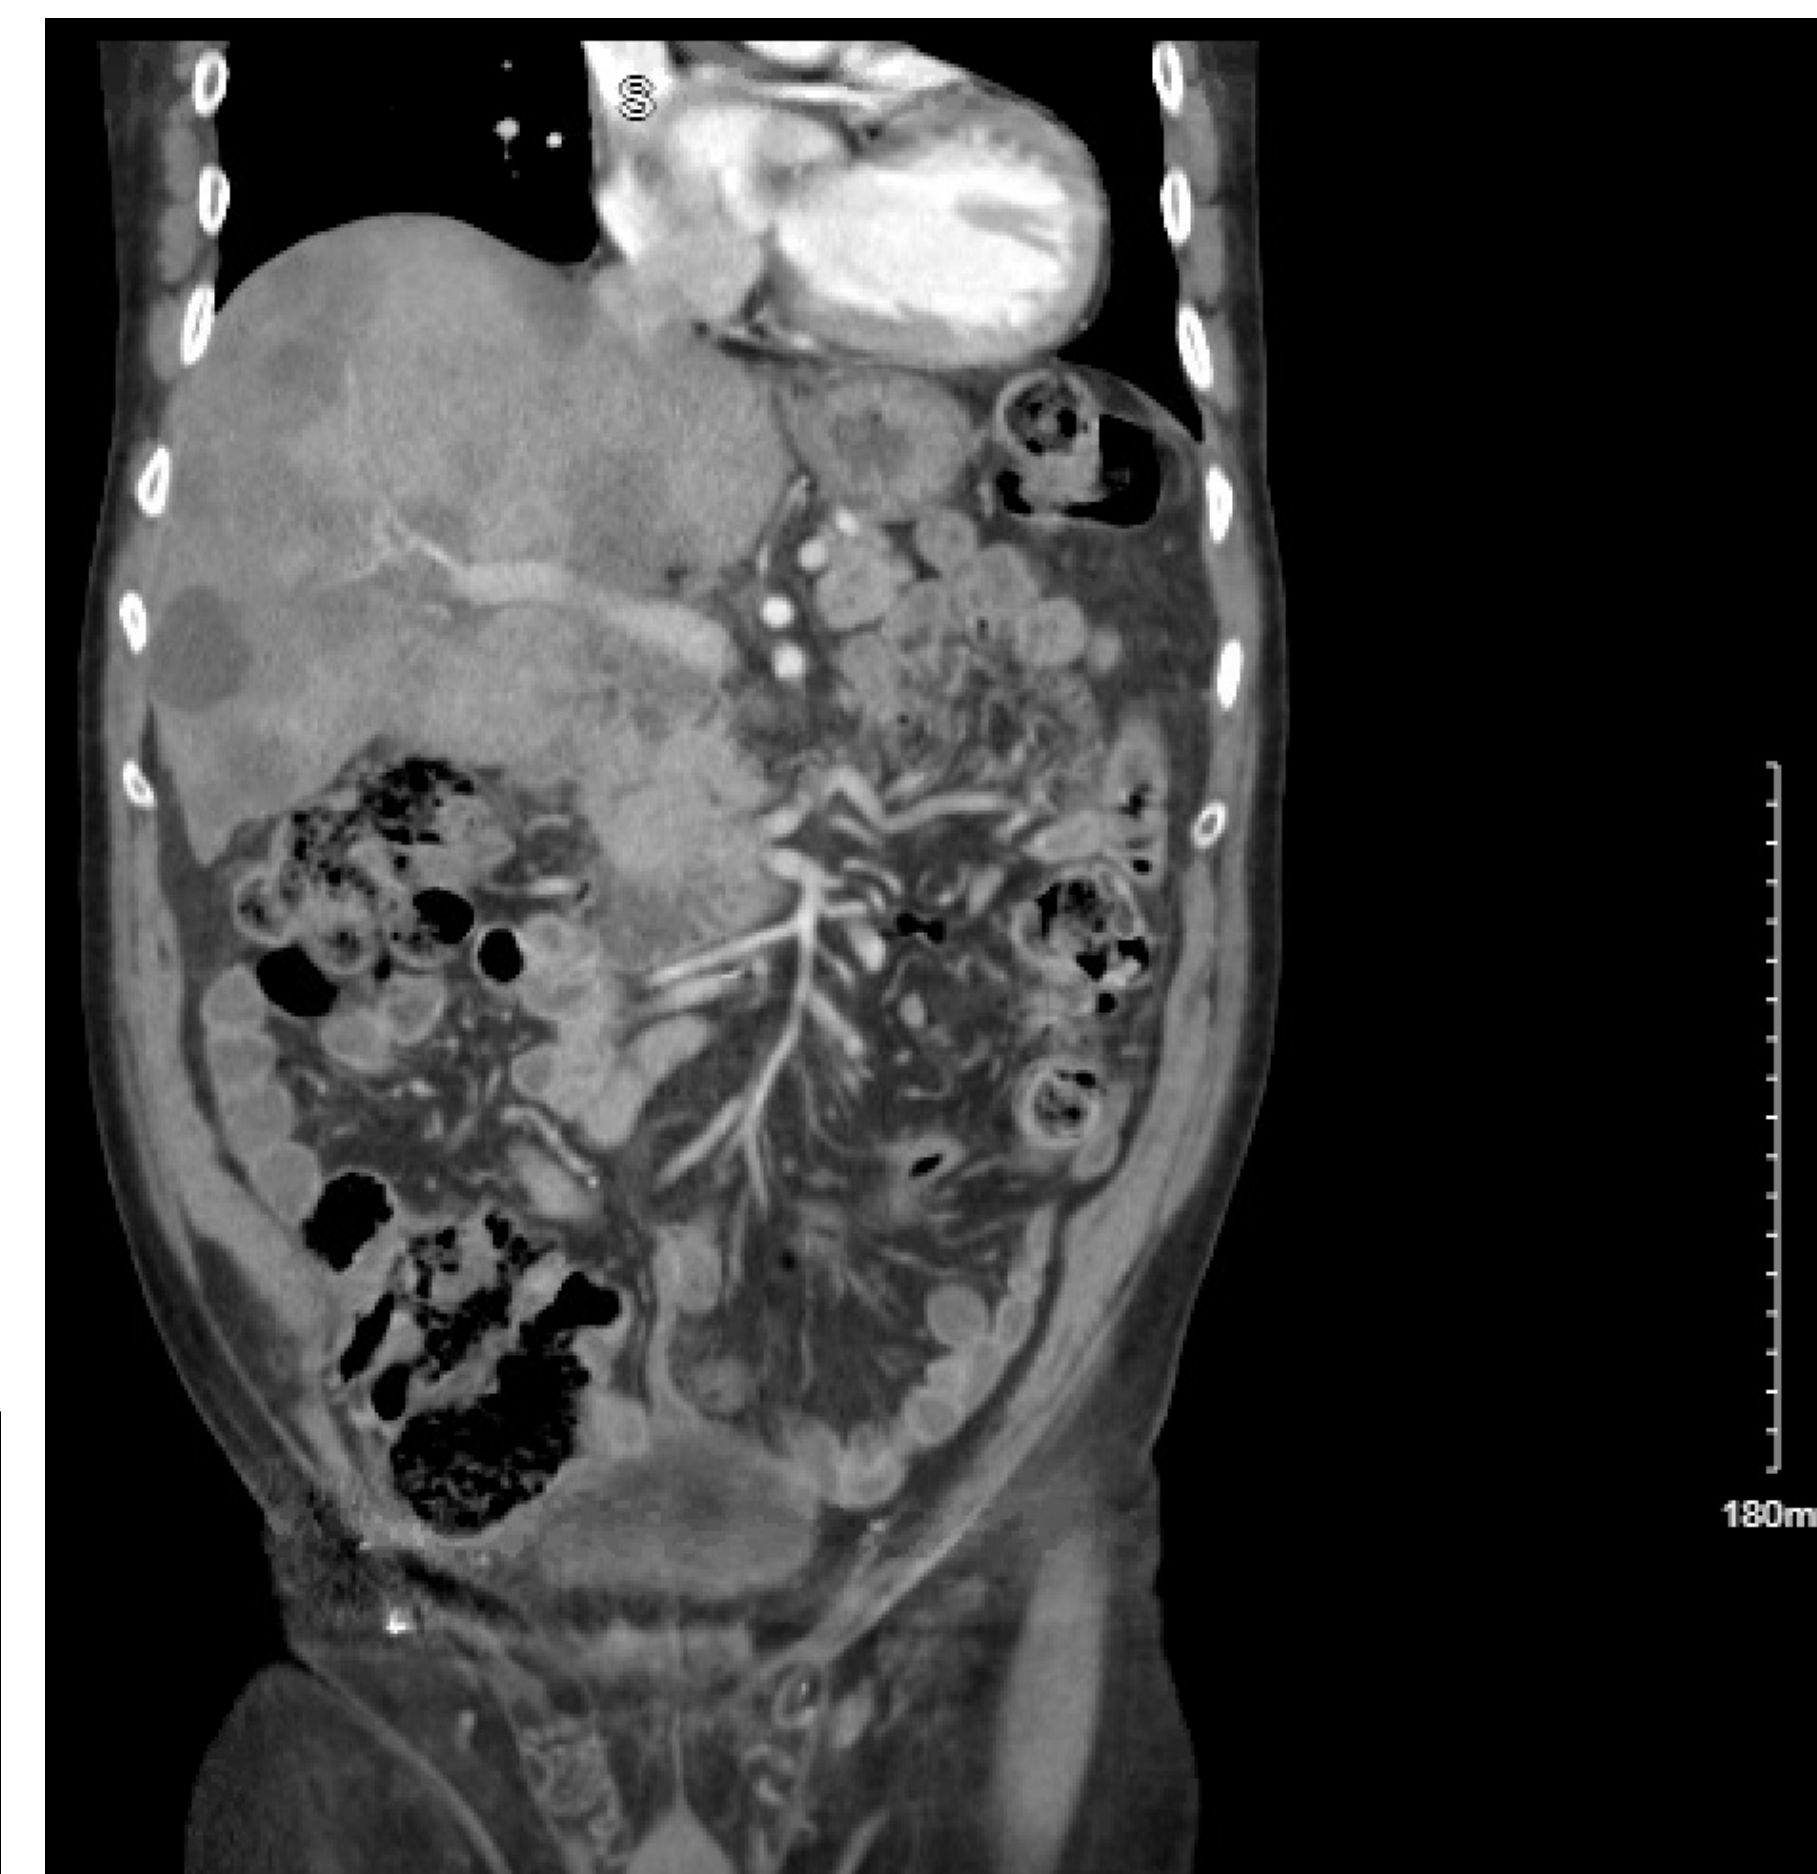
Initial CT of the abdomen and pelvis with contrast performed on admission that demonstrates multiple space-occupying lesions in the liver and mild hepatomegaly
